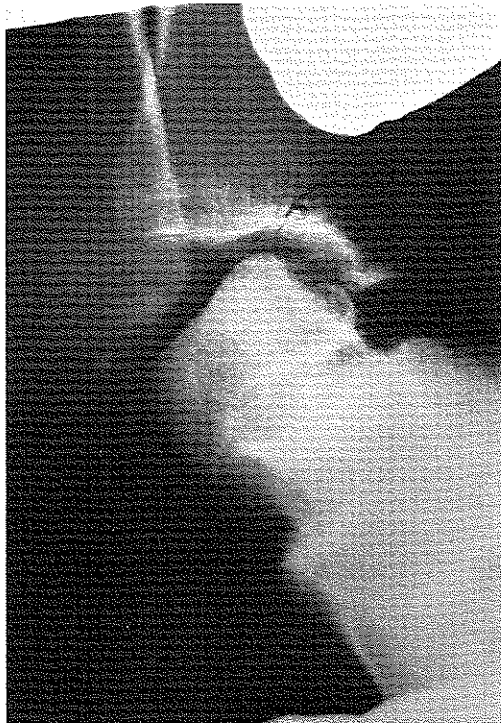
A positive stress inversion radiograph.
